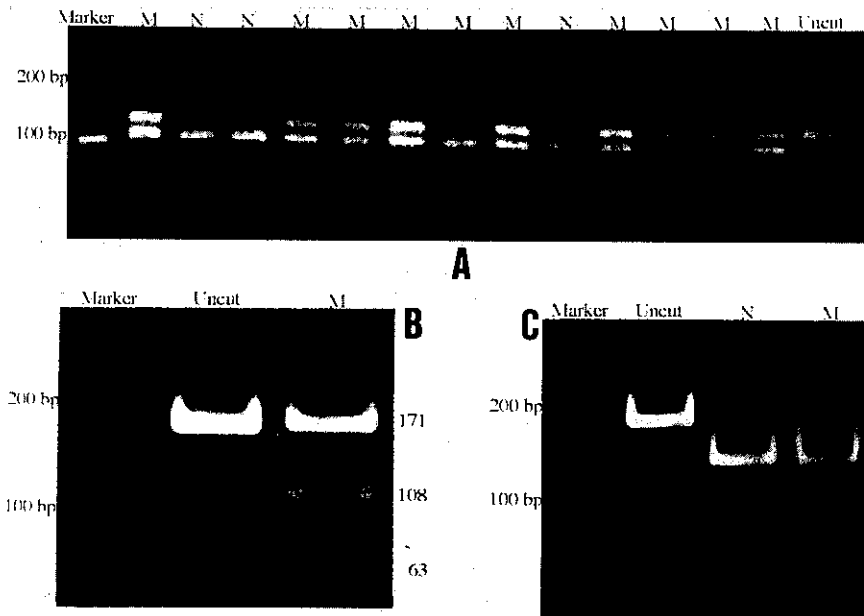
Result of PCR-RFLP analysis of *K-ras* gene by using restriction enzymes (M, mutant type; N, wild type). A. Detection of 1st and/or 2nd base mutation of codon 12 using *Msp* I enzyme. B. Detection of CAA-to-CTA mutation of codon 61 using *Xba* I enzyme. C. Detection of CAA-to-CGA mutation of codon 61 using *Taq* I enzyme.
